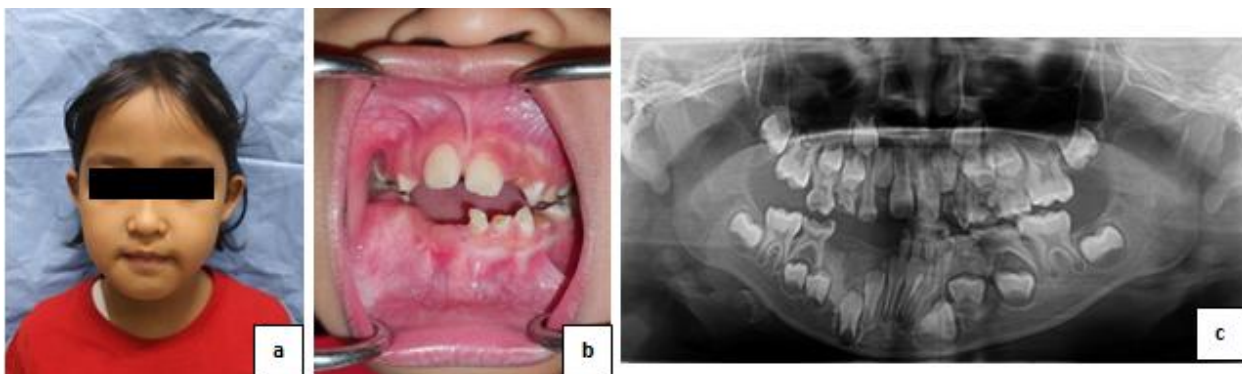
(a,b) Recurrence lesion on both clinical and (c) radiograph findings
